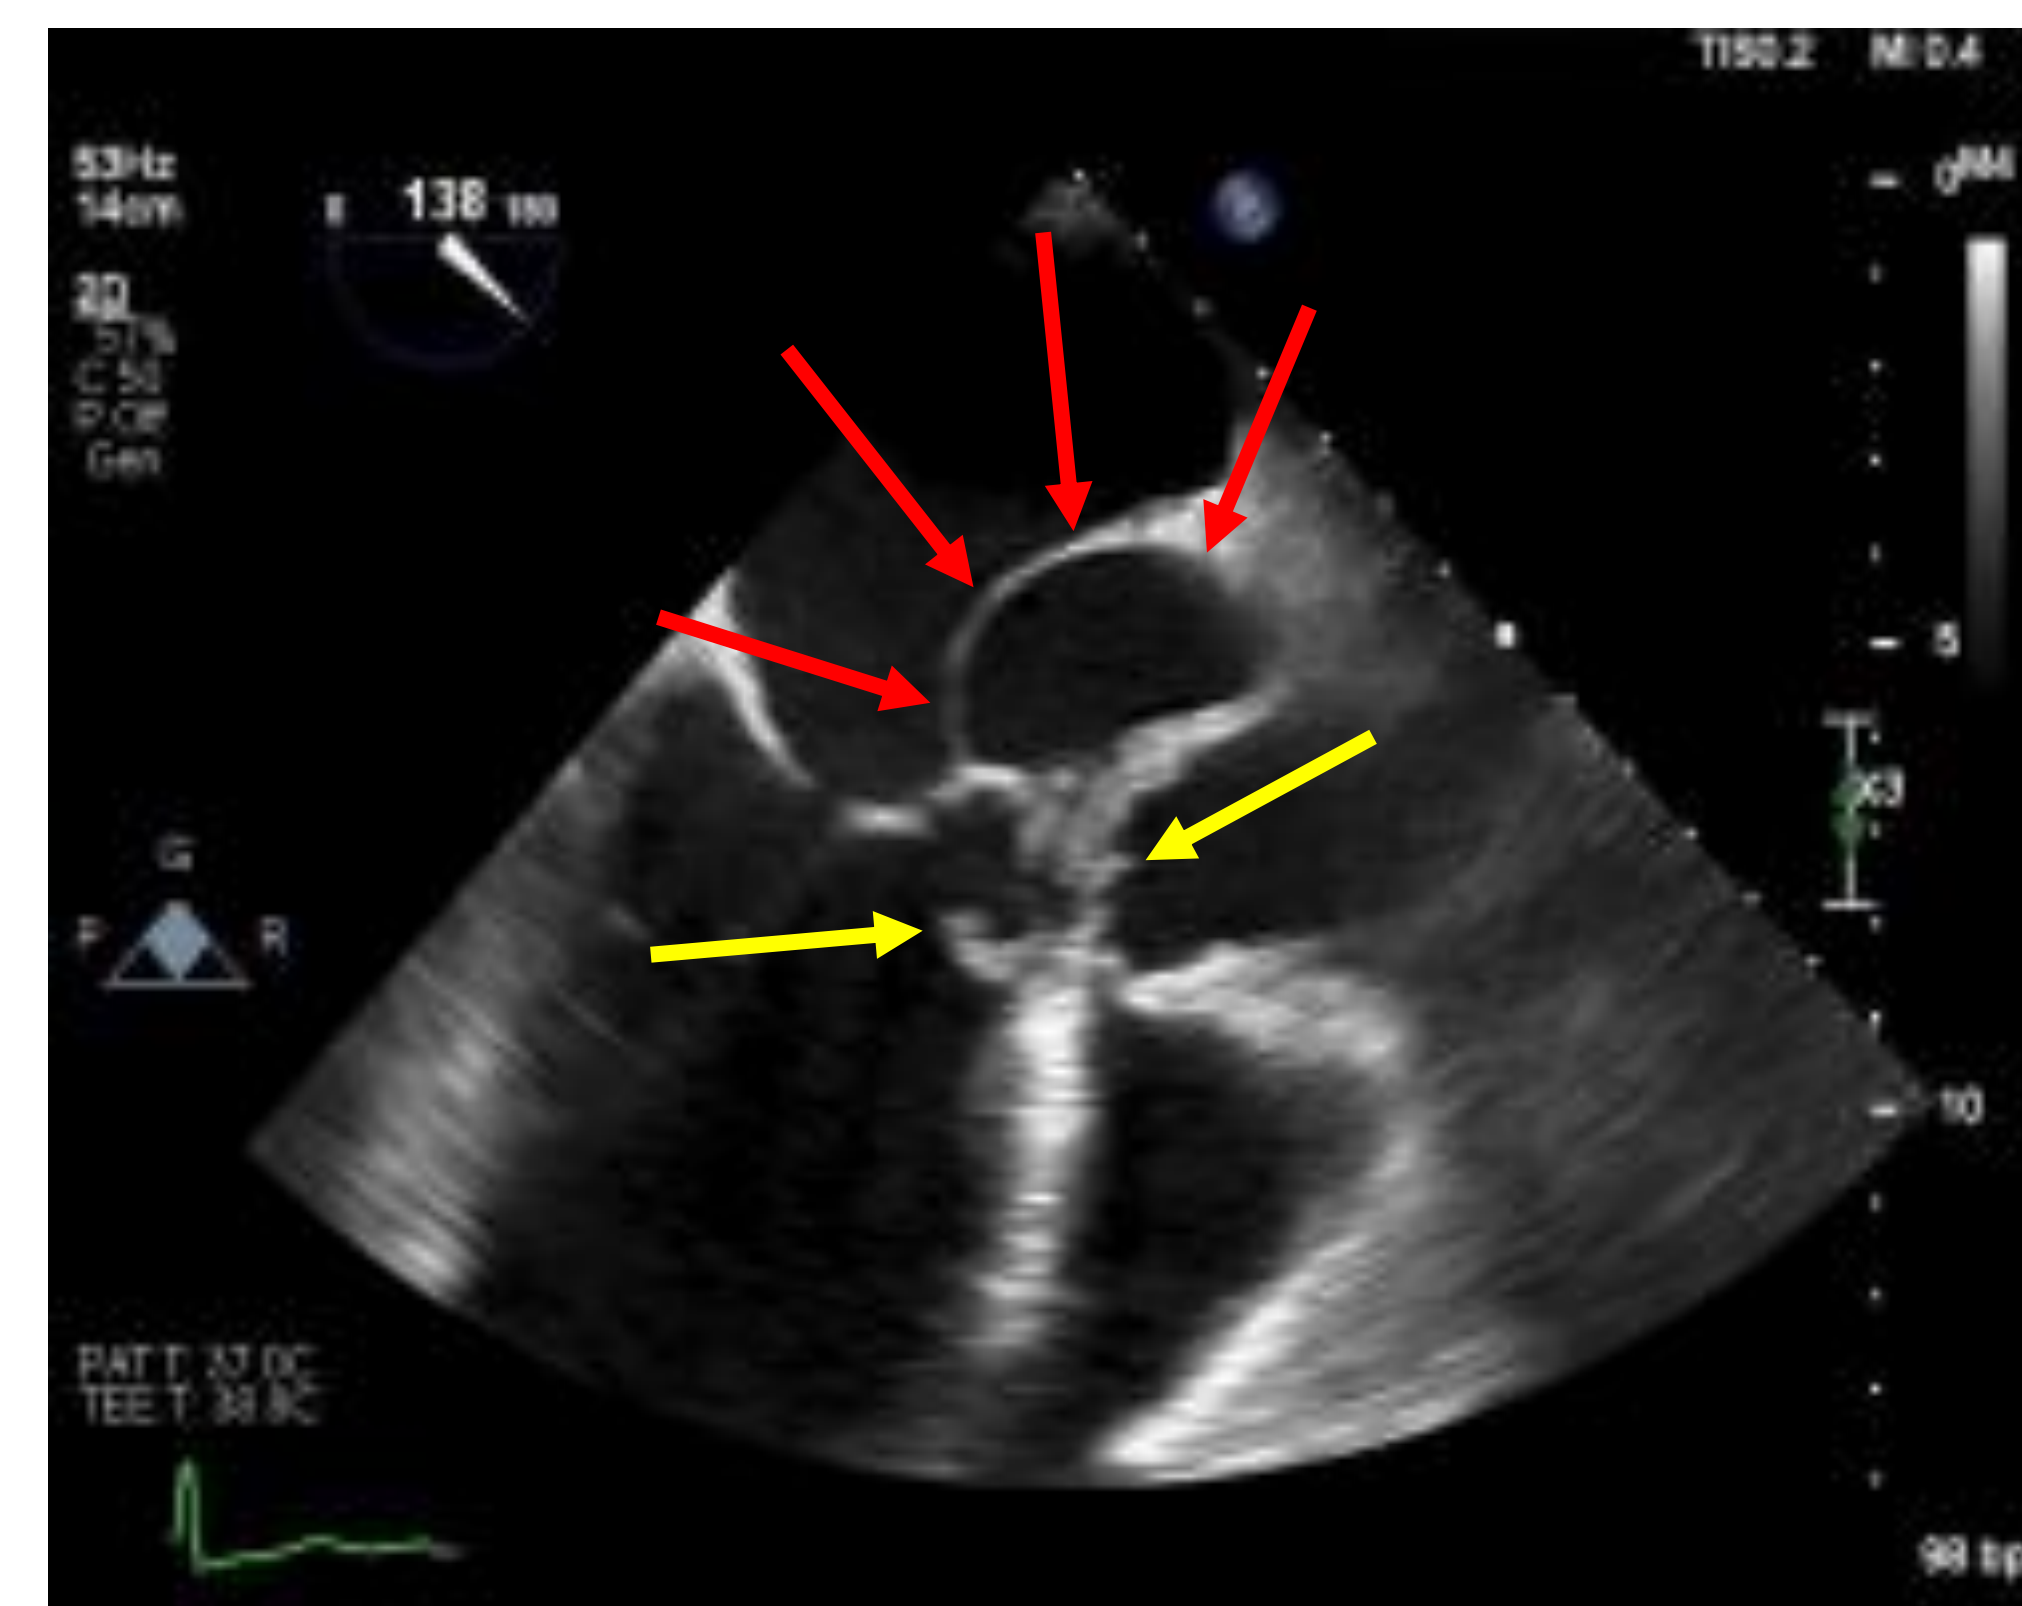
Parasternal long axis view of bedside TEE, demonstrating thick aortic valve echo-densities, suggestive of vegetations (yellow arrows), and left coronary sinus of Valsalva aneurysm (red arrows)
